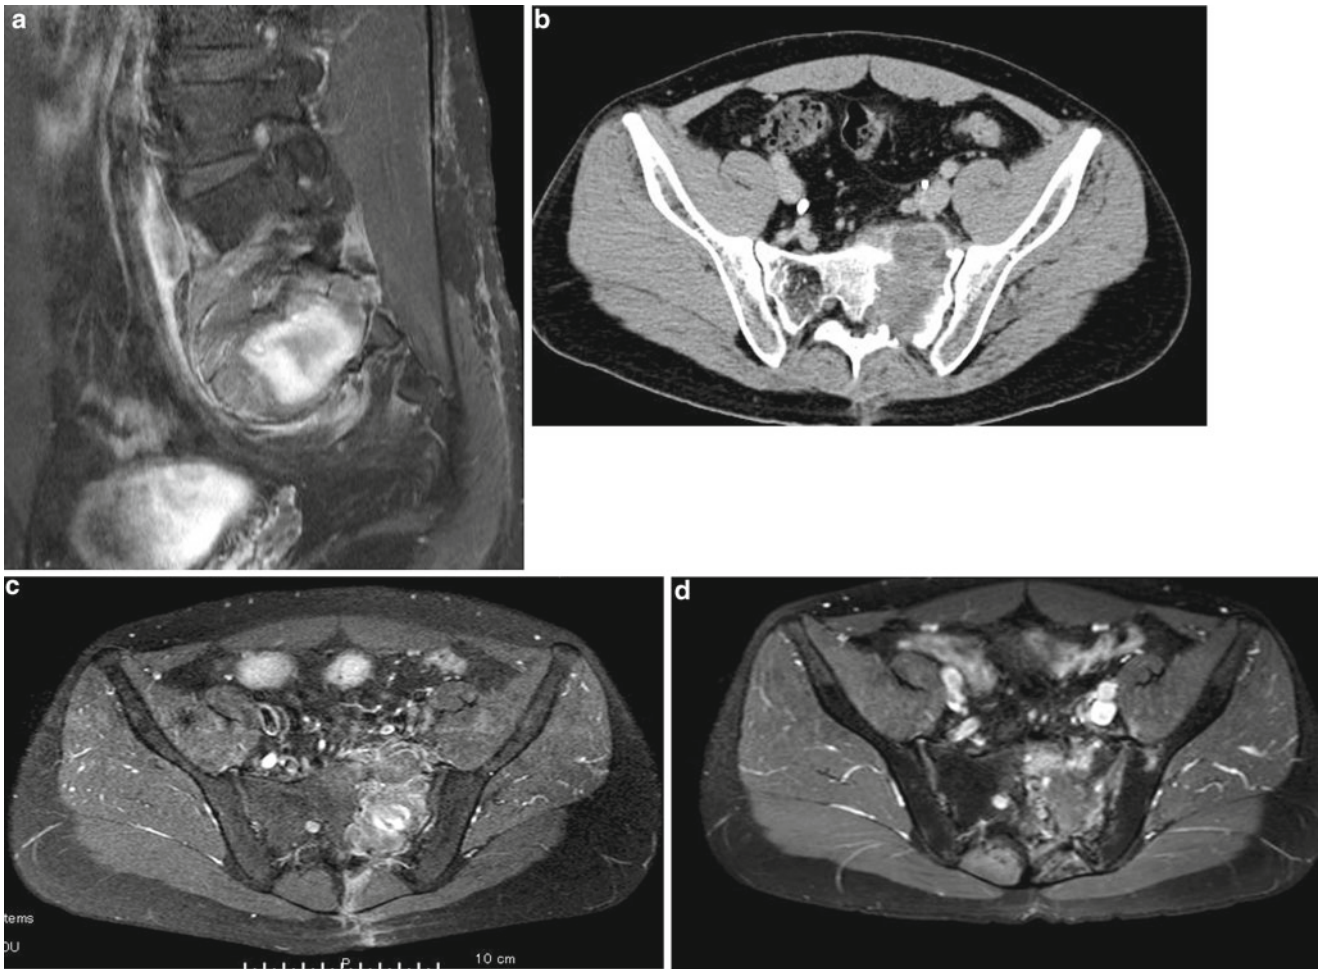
(a) T1-weighted sagittal MRI with a contrast medium before carbon ion radiotherapy. (b) CT image with a contrast medium before carbon ion radiotherapy. (c) T1-weighted axial MRI with a
